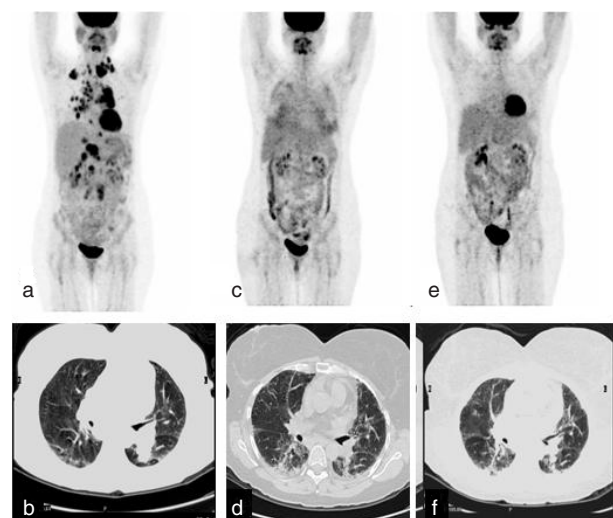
Pre-treatment PET-CT scan shows extensive FDG-avid lymphadenopathy but no FDG uptake in lung parenchyma (a, b). PET-CT three months after the acute presentation of pneumonitis shows diffuse FDG uptake in the lungs consistent with bilateral inflammatory process and reticular pattern predominantly in subpleural areas (c,d). The uptake in the lungs normalised after further four months of treatment with corticosteroids but the parenchymal changes persist (e,f).
